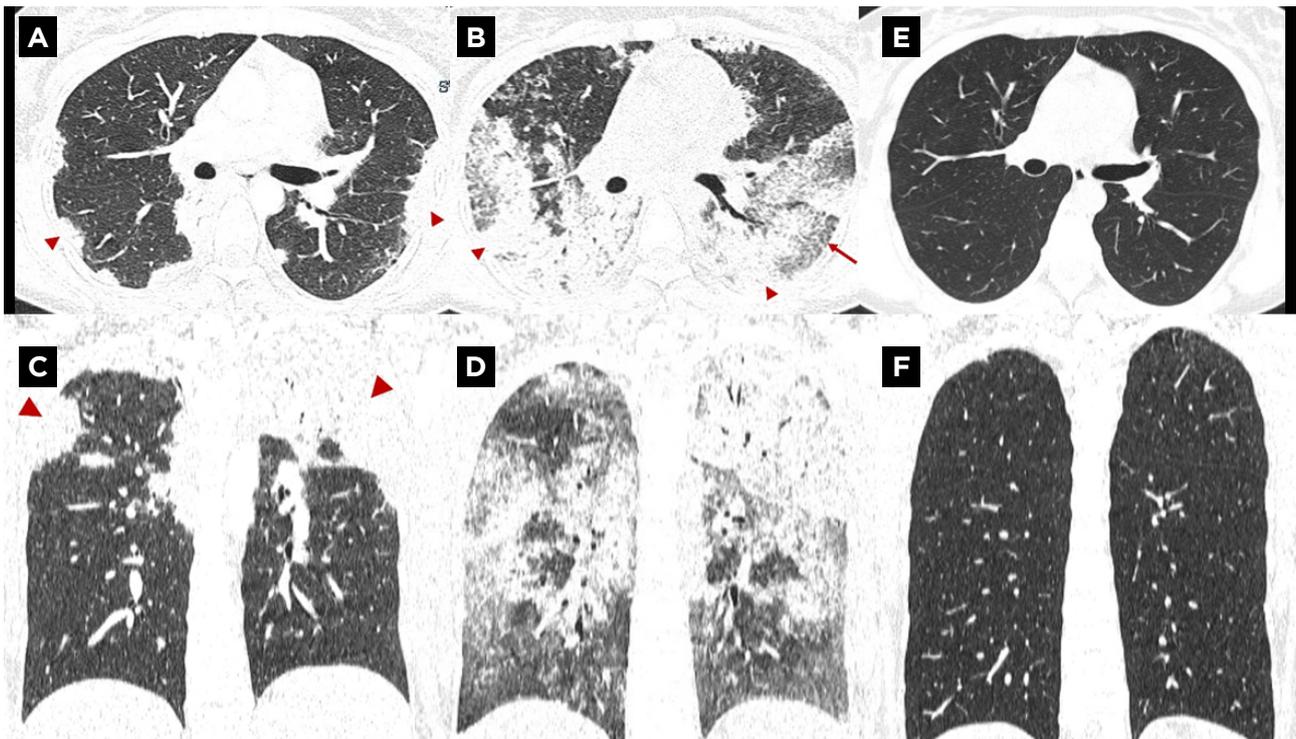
High-resolution thoracic CT scan images. A) Axial image of the first CT scan at the level of the inferior lung lobes demonstrates bilateral and peripheral consolidations. B) Axial image of the second CT scan at the same level shows significant worsening of the parenchymal lung findings. There are more extensive bilateral and diffuse lung consolidations (arrowheads) and new areas of ground-glass opacities with superimposed smooth intralobular and interlobular septal thickening, producing the crazy-paving pattern (arrow). These findings are compatible with acute/subacute diffuse alveolar hemorrhage in this clinical scenario. C and D) Coronal image reconstructions show the extensive craniocaudal involvement of both lungs, again demonstrating the worsening of lung damage from the first CT scan to the second. E and F) Axial and coronal images of the posttreatment CT scan demonstrates a remarkable response to treatment, with complete resolution of the parenchymal lung findings.
